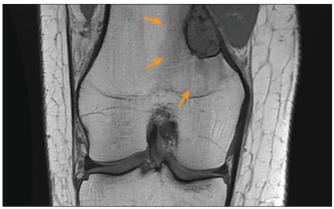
Coronal, T1-weighted magnetic resonance image with mostly isointense internal T1 signal to muscle, and mild surrounding marrow and soft tissue edema with corresponding decreased T1 marrow signal surrounding the lesion (indicated by arrows), indicative of bone stress injury.²
